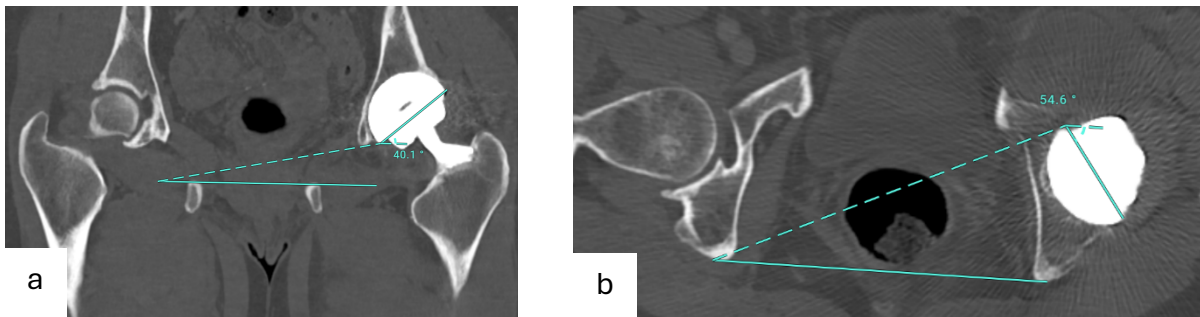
Coronal (a) and axial (b) CT images of the respectively the cup inclination of  $40^\circ$  and anteversion of  $35^\circ$  ( $90^\circ - 54.6^\circ = 35.4^\circ$ ). Adequate anterior bony coverage of the cup is noted on the axial image (b).
